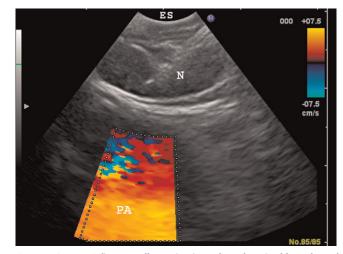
EUS fine-needle aspiration of a subcarinal lymph node (station 7) with an EBUS scope. Notice the smaller ultrasound range in comparison with an investigation with a conventional EUS scope (see Fig. 6.7). Es, esophagus; N, needle; PA, pulmonary artery.
